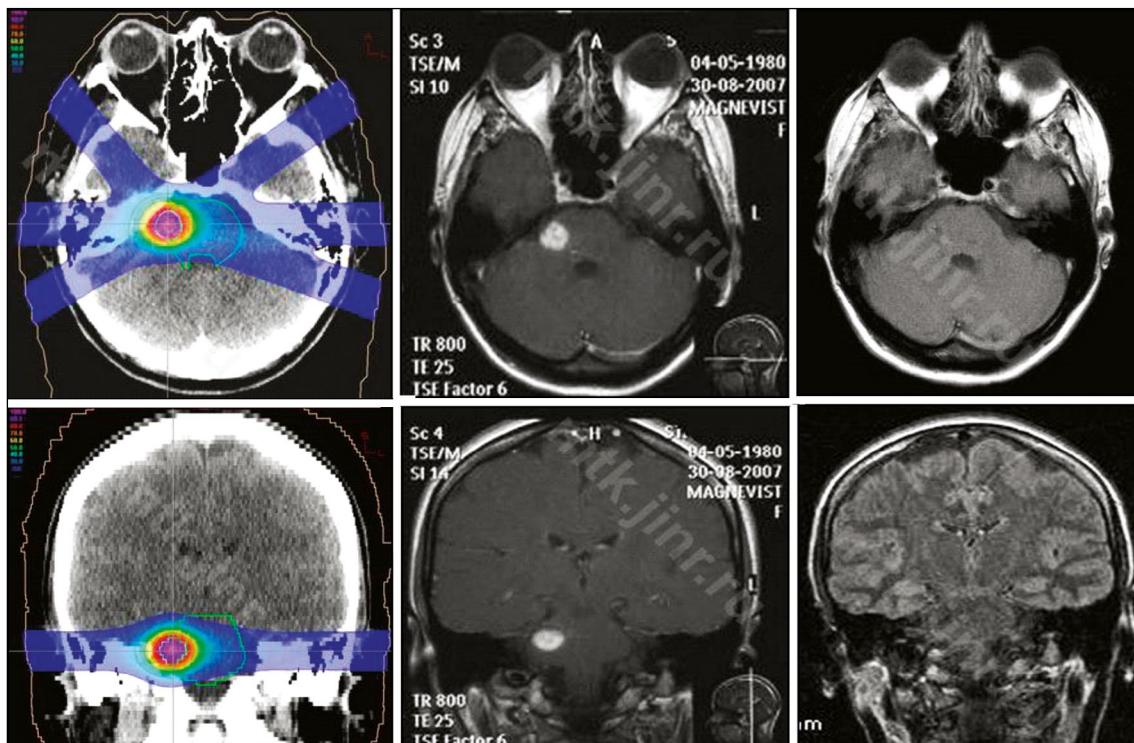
骨膜海绵状血管瘤质子放射外科手术计划: 治疗前和治疗后 3 个月(海绵状血管瘤完全吸收)的 MRI 对比。
